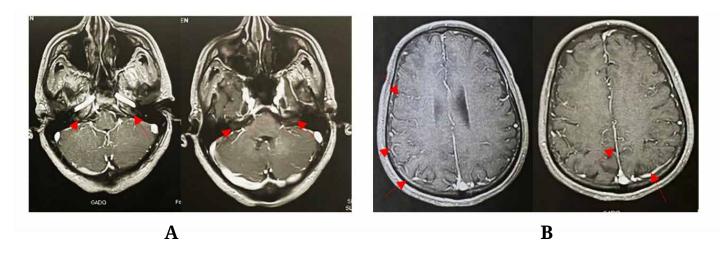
Axial brain MRI on T1-weighted with Gadolinium enhancement of the first case report. A: bilateral acoustic-facial bundle. B: leptomeningeal contrast enhancement.
